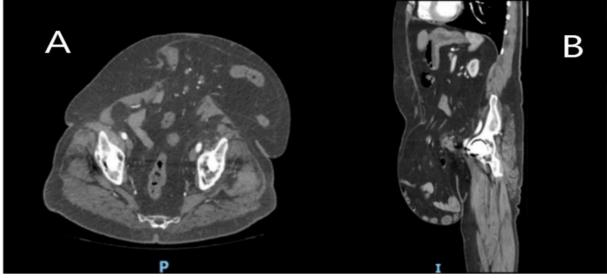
Contrast-enhanced CT of the abdomen. A-transverse view, B-sagittal view
